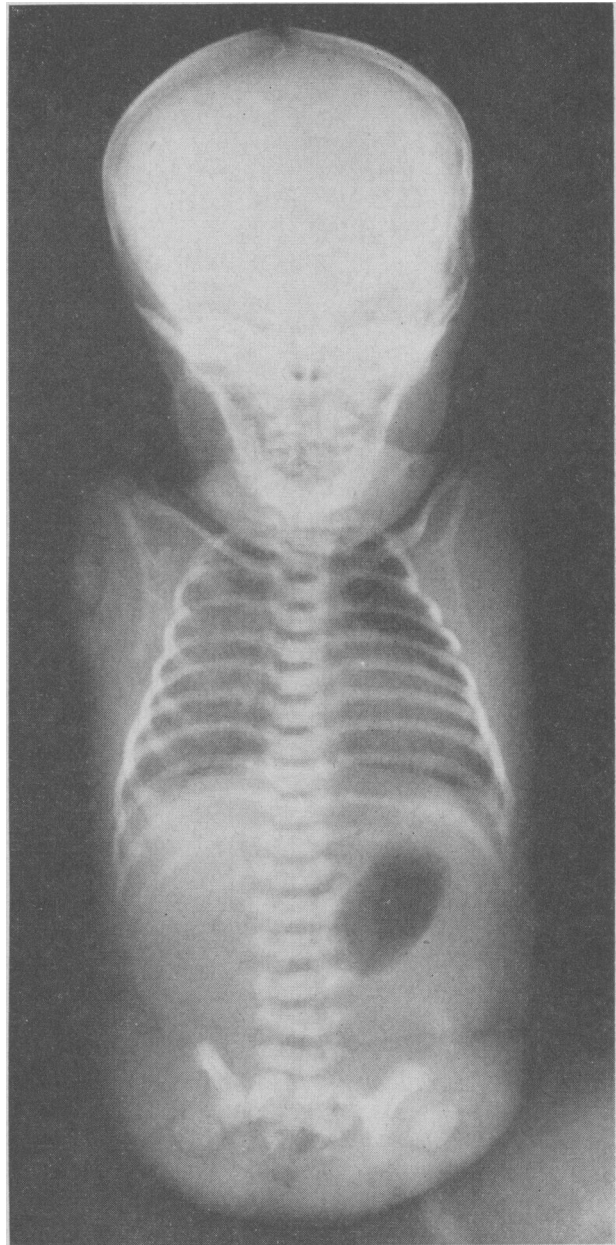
Radiograph demonstrates severely malformed skeletal, cardiac, pulmonary, gastrointestinal and genitourinary systems.
